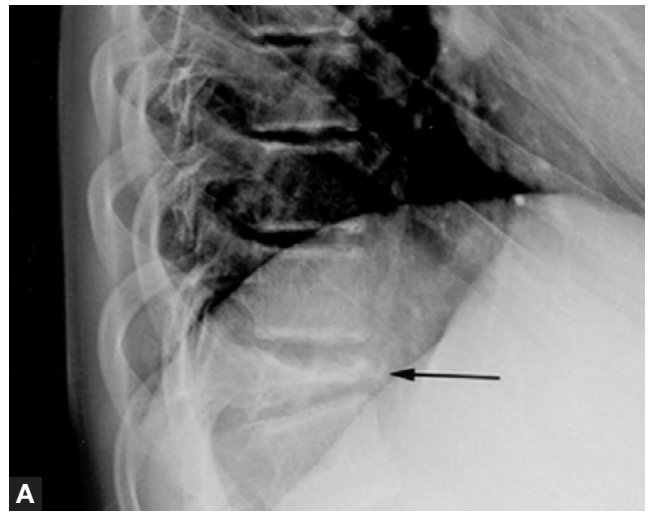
At 3-month follow-up, anteroposterior and lateral radiographs of the spine reveal “vertebra plana” lesion characteristic of Langerhans cell histiocytosis lesions in the spine.
